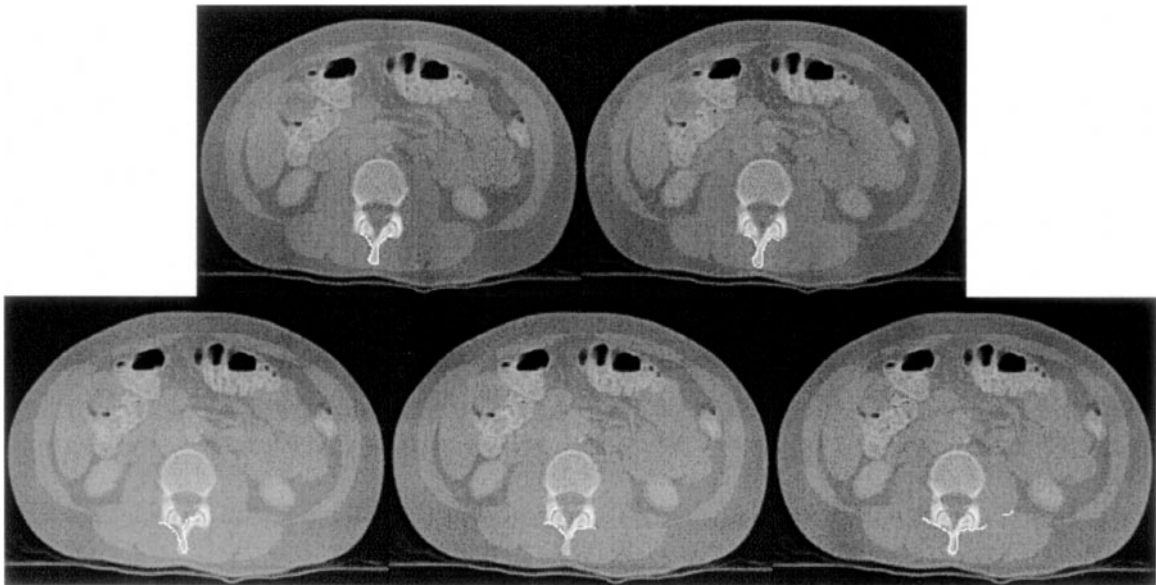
Visual results of registering all five point sets to the surface of vertebra L2 on Patient I. From left to right on the top row, points from L1 and L2 are shown on a single slice of the CT image set of L2. From left to right on the bottom row, points from L3 through L5 are shown on the same slice of the CT image set of L2. Points are projected onto the closest 5-mm plane for plotting.
